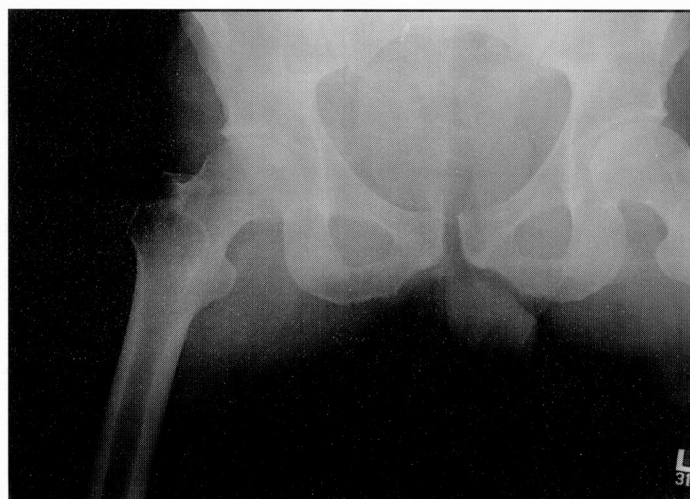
X-ray of pelvis post-application of TPOD® device.
